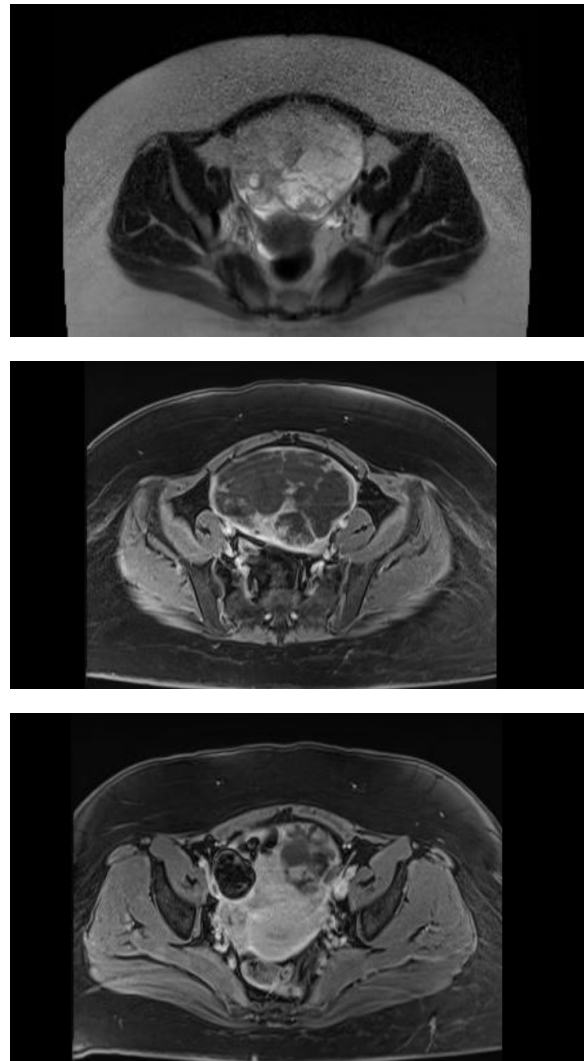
MRI sequences show a large 130*80*135 mm solid and cystic pelvic mass arising from the left ovary with multiple irregular internal septations, mural nodules and solid components with marked enhancement of its internal septations and solid components. Tumor markers, CA 125 and CEA were within normal limits.
